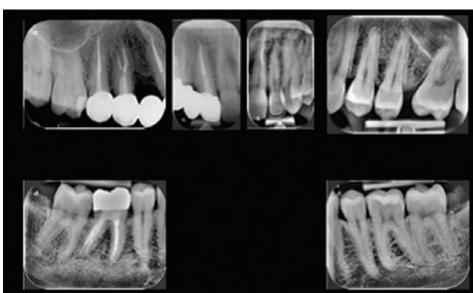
Final radiographic examination
